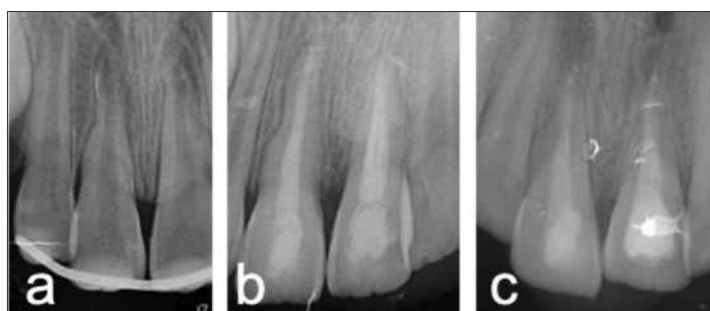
Radiographic appearance of case 7; a – preoperative; b – postoperative; c – postoperative 24-month follow-up
